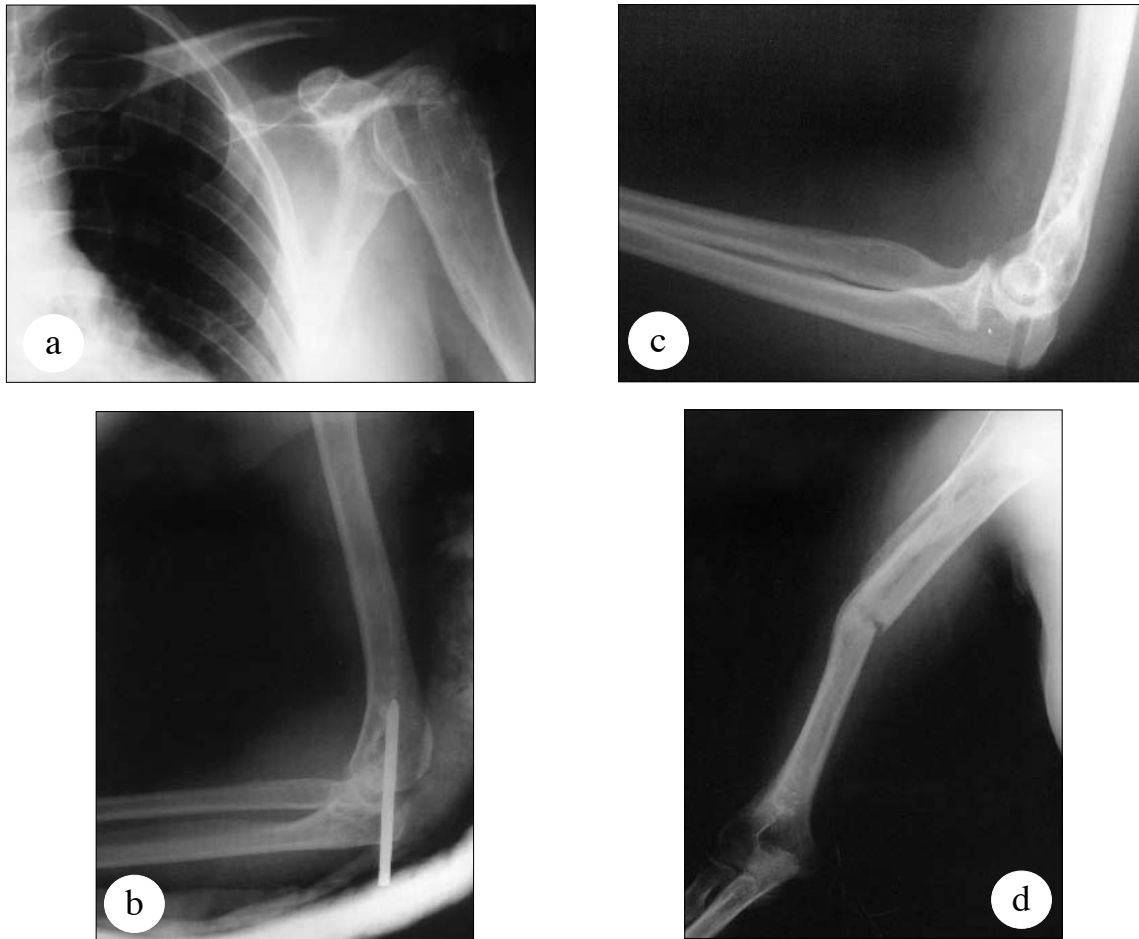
Final x-rays of the left shoulder, elbow and right humerus a) Fracture of greater tuberosity reduced after closed reduction of the shoulder. b) After closed reduction the elbow was fixed in 90° flexion with a Kirschner wire. c) At 3 weeks, after removal of the Kirschner wire. d) The healed comminuted humeral fracture at 12 weeks.
